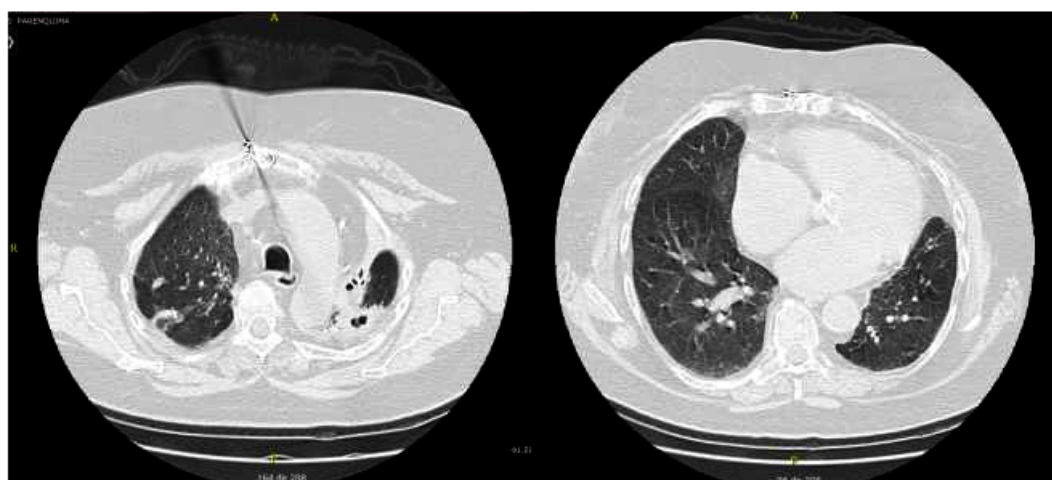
In C, CT scans of the chest demonstrated centrilobular emphysema coexisting with fibrotic lesions and atelectasis, mainly in the left upper lobe (left scan), and cardiomegaly (right scan).
